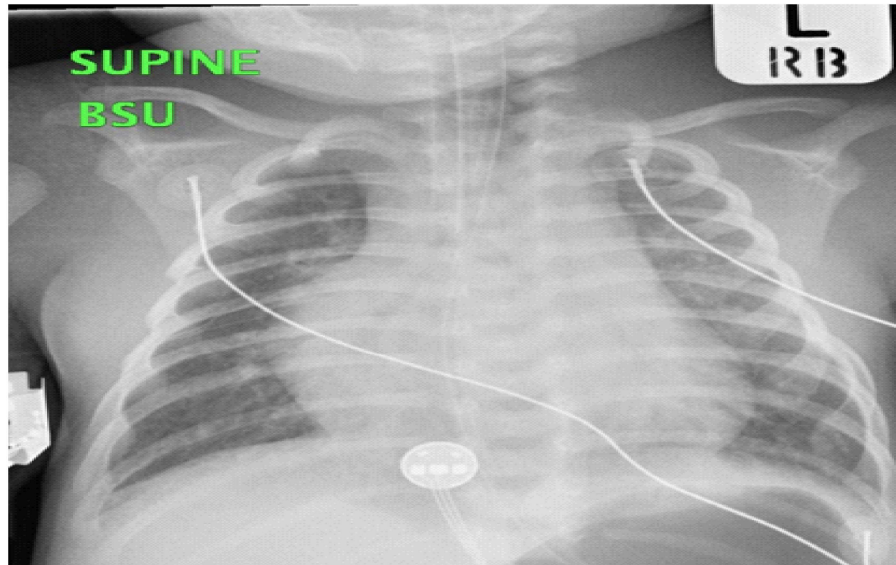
A supine anterior posterior (AP) chest radiograph of the neonate showing cardiomegaly (CTR- 0.62). There is associated hyperinflation of the lung fields with increased Broncho vascular markings. Endotracheal and nasogastric tubes are seen in-situ. Echocardiographic leads are also noticed.
